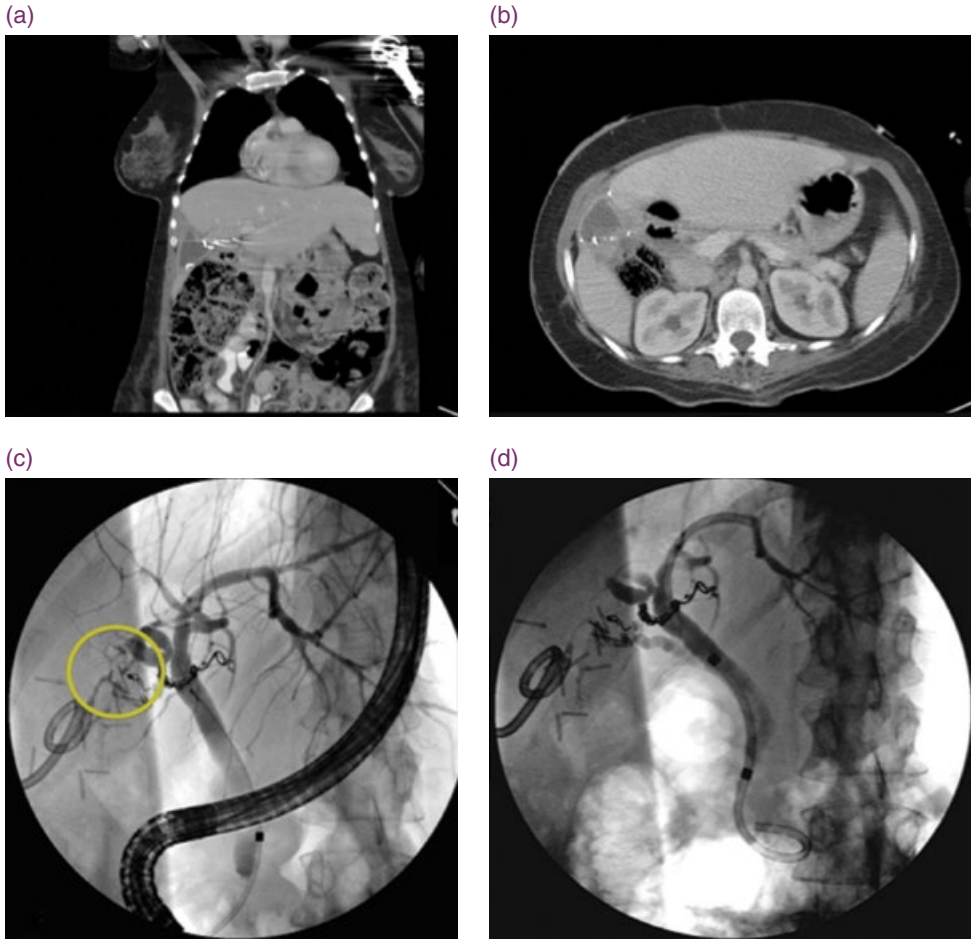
Bile leak after partial right-sided hepatectomy. (a) Computed tomography (CT) scan showing the biloma. (b) CT, sagittal view. (c) A small bile leak became apparent during cholangiography. (d) A double pigtail stent was inserted.
